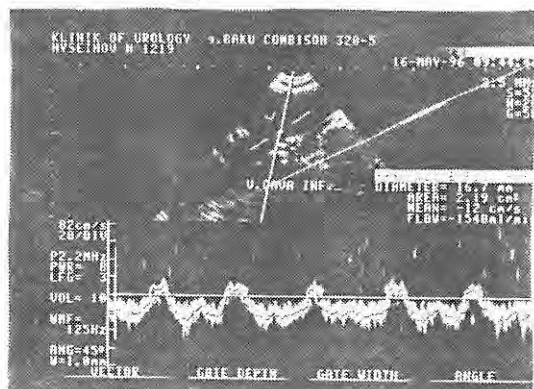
Duplex scanning of the inferior vena cava shows B-mode ultrasound image (longitudinal section) and corresponding normal triphasic Doppler spectrum in a patient with chronic pyelonephritis
